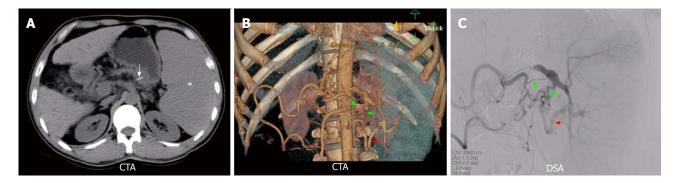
Imaging studies. A: After ligation of splenic artery treatment, abdominal computed tomography showed that the size of the spleen was enlarged (white star). Ischemic necrosis was not seen in the spleen. However, the bio-clamp (white arrow) was seen in the splenic artery area; B and C: Splenic compensatory arteries: the dorsal pancreatic artery (green arrow), and the left gastro-epiploic artery (red arrow). CTA: Computed tomography angiogram; DSA: Digital subtraction angiography.
